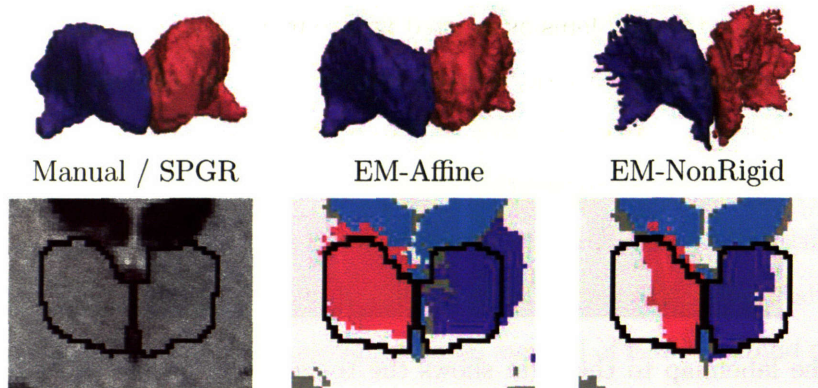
The images to the left show the manual segmentation of the thalamus in 3D and outlined in black on the slice of the MR image. The other two columns feature the segmentation of the two implementations EM-Affine and EM-NonRigid. EM-NonRigid underestimates the size of the thalamus as the non-rigid registration approach cannot properly register this region due to the similar intensity pattern between thalamus and white matter. EM-Affine performed much better but a mis-registration along the vertical direction is visible in the images.
